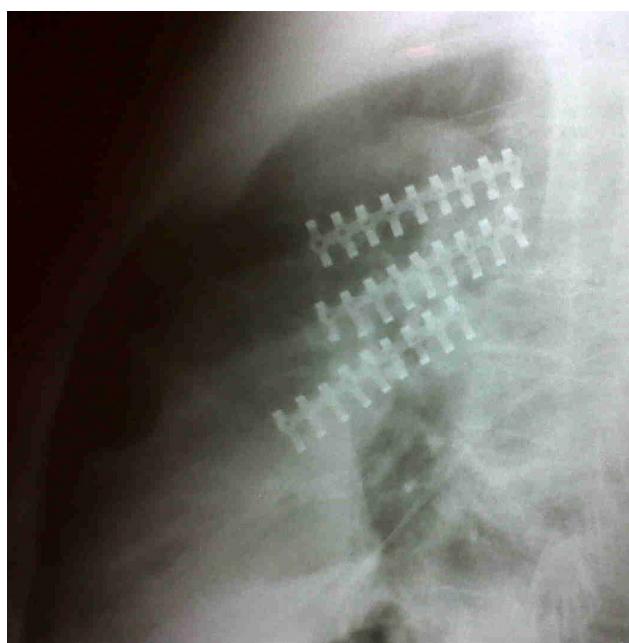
Postsurgical control. Chest X-ray. Lateral projection that shows a satisfactory correction of left rib fractures by placing osteosynthesis material.
